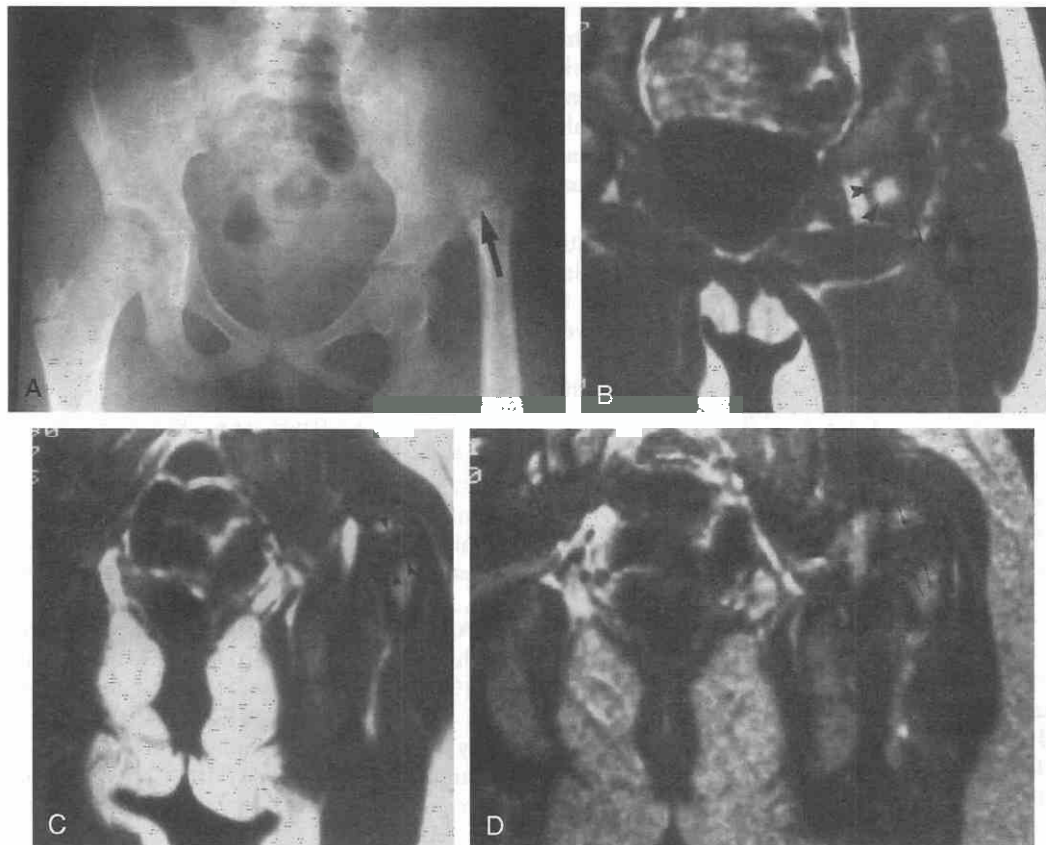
Proximal femoral focal deficiency in a 6-year-old child. A, Pelvic radiograph shows deficiency of the proximal femur with lucent cleft in upper portion of remaining femur (*large arrow*). B, Coronal T1-weighted MRI was performed to evaluate for possible surgical reconstruction. The image shows a capital femoral epiphysis, seen as high signal intensity (fatty marrow) not well visualized on the radiograph (*large arrowheads*). The femoral head, however, is not connected to the remainder of the femur, where there is intervening tissue (*open arrow*), and thus cannot be used for reconstruction. C, More posteriorly, a coronal T1-weighted MR image shows the upper femur with a low-signal-intensity gap at its upper extent (*small arrowheads*). D, T2-weighted coronal MR image shows that this area maintains low signal intensity, consistent with fibrous tissue (*small arrows*) rather than pseudoarthrosis, which may show high signal intensity.
